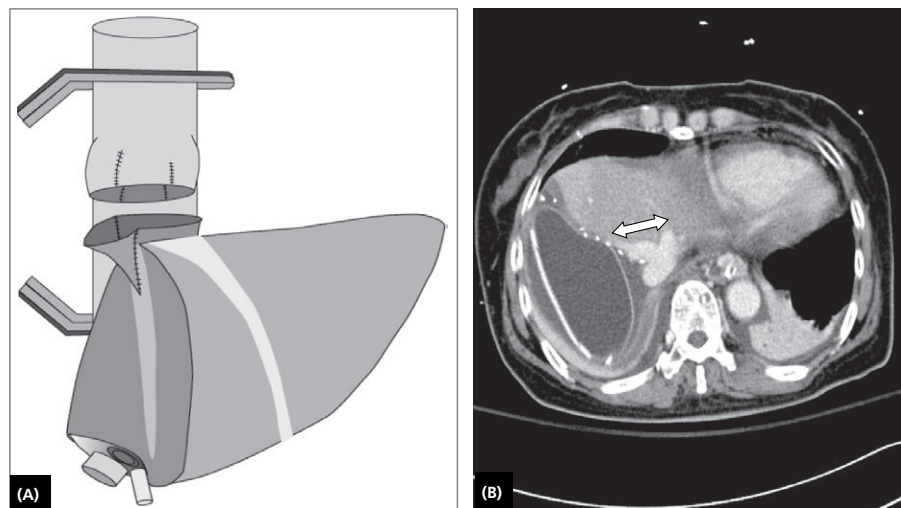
Reconstruction of the hepatic vein in left lobe, living donor liver transplantation. (A) Anastomosis between the donor and recipient's maximally enlarged, common hepatic veins is performed by clamping the supra- and infrahepatic inferior vena cava and by venovenous bypass. (B) Follow-up CT scan obtained on postoperative day 7 showed wide hepatic vein outflow and tissue expander filled with saline solution to prevent torsion of the hepatic vein anastomosis until there was adequate regeneration of the implanted graft.
